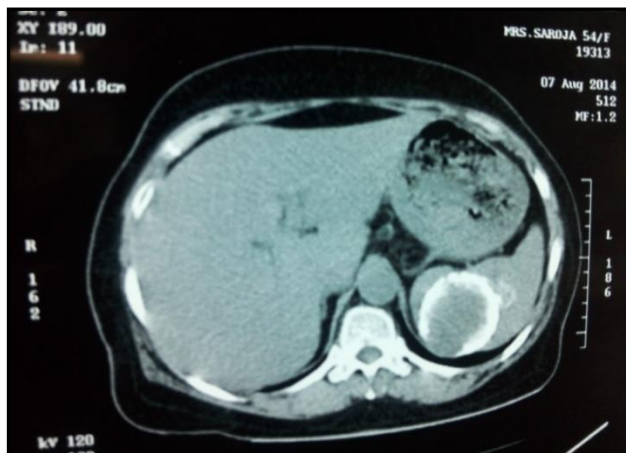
Computed tomography of abdomen showed large mass of 6.3x6.4cm with peripheral rim of calcification in the spleen.
